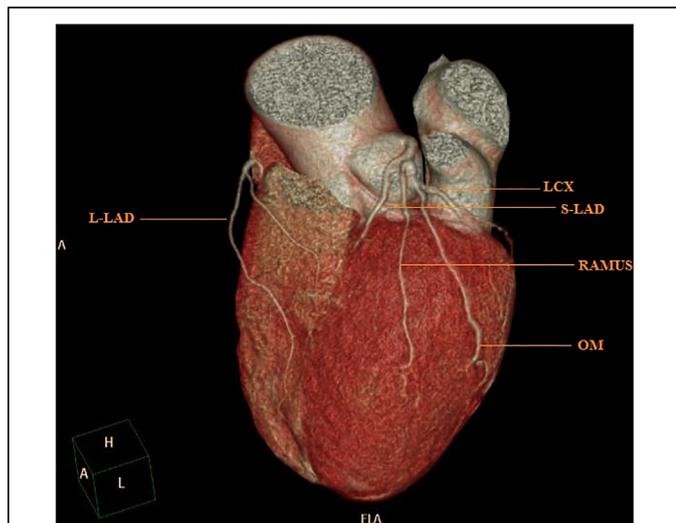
(A): Colored 3D volume rendered coronary computed tomography angiography (CCTA) showed both the long LAD and right coronary artery (RCA) originating from the right coronary sinus (RCS). (B) Colored 3D volume rendered CCTA showed short LAD originated from the left main coronary artery (LMCA) and terminated in the proximal AIVS. Abbreviations:
